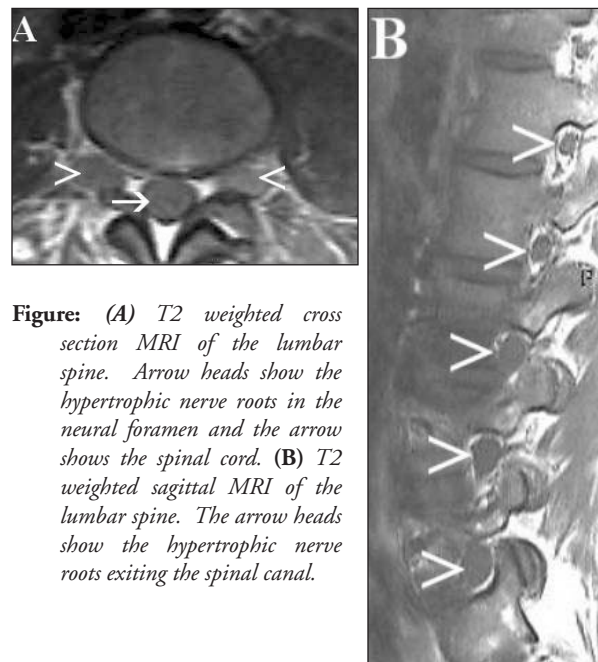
(A) T2 weighted cross section MRI of the lumbar spine. Arrow heads show the hypertrophic nerve roots in the neural foramen and the arrow shows the spinal cord. (B) T2 weighted sagittal MRI of the lumbar spine. The arrow heads show the hypertrophic nerve roots exiting the spinal canal.
